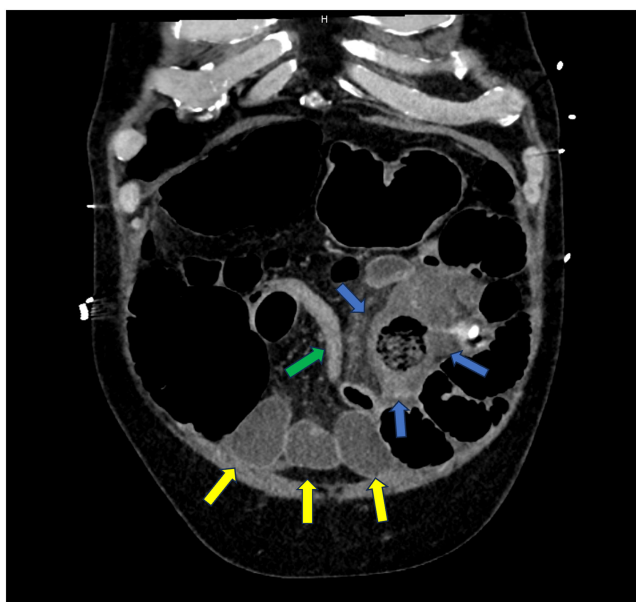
CT abdomen and pelvis with IV contrast, coronal view, showing a decompressed loop of small intestine (green arrow), phlegmon and contained perforation (blue arrows), and dilated fluid-filled small intestine (yellow arrows).
